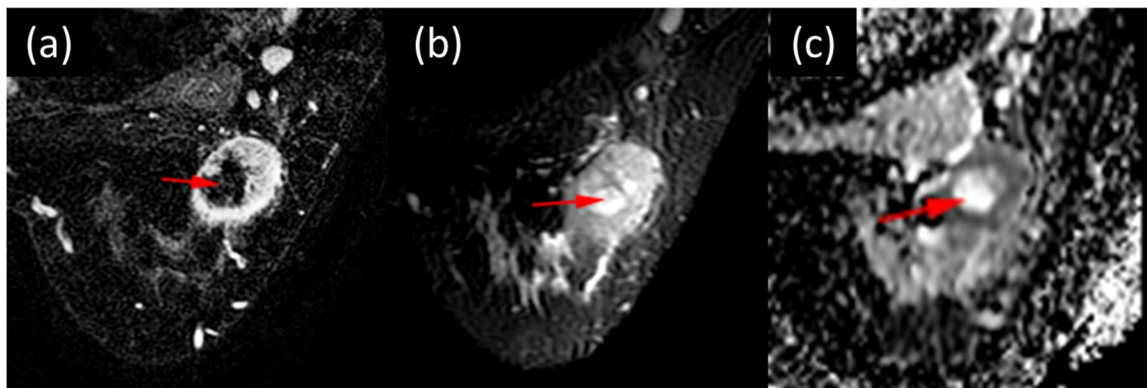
Necrotic index carcinoma with pathological non-complete response after neoadjuvant systemic therapy in a 30-year-old woman with TNBC of the left breast. The volume of necrotic material was 4 cm³, and the percent of the total tumor volume occupied by necrosis was 17%. (a) Axial fat-suppressed early-phase dynamic contrast-enhanced image shows central non-enhancing area representing necrosis (arrow). (b) Axial fat-suppressed T2-weighted image shows necrosis as a central area of high signal intensity (arrow). (c) Axial apparent diffusion coefficient map shows shine-through corresponding to central area of necrosis (arrow).
